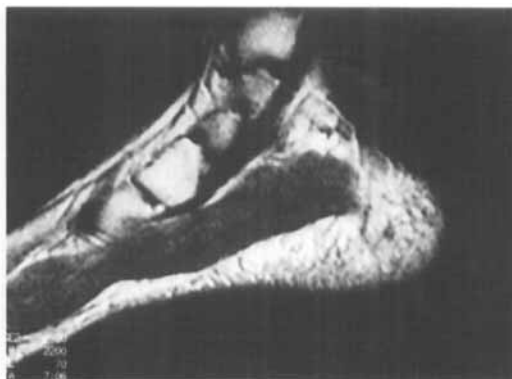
T2-weighted MRI images of a normal foot. Note the tendon continuity under the navicular bone.
